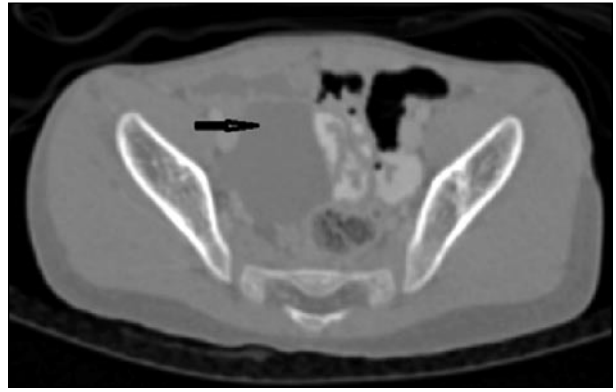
CT scan of pelvis showing cystic lymphangioma impacted in the right side of pelvis (arrow)
